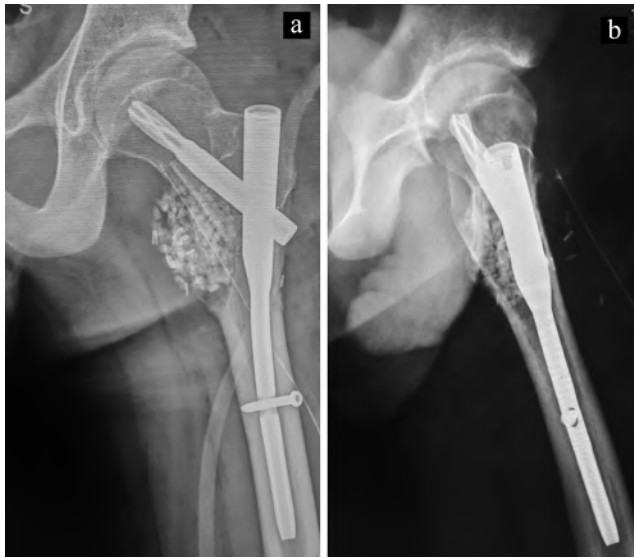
Post-operative radiograph following curettage of the cyst, with in situ fibular strut graft, calcium phosphate granules and proximal femoral nail in anteroposterior view in 5a and lateral view in 5b image
